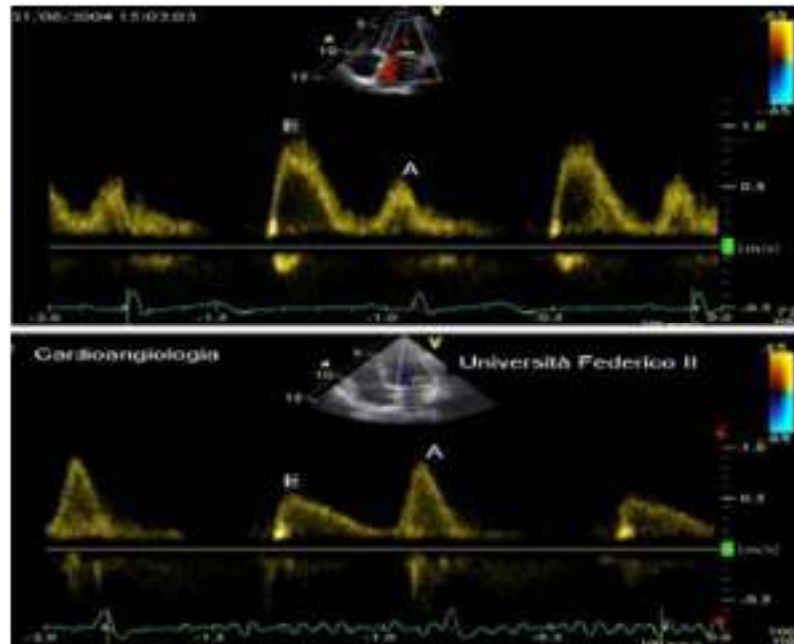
Measurement of doppler trans-mitral indices of diastolic function.
